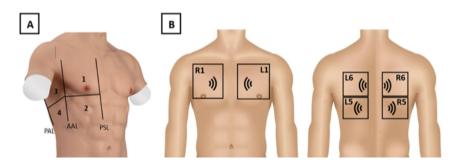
Lung Ultrasound Protocols. (A) The four chest areas per side considered for complete eight-zone lung ultrasound examination, used to evaluate the presence of interstitial syndrome. According to Volpicelli et al, the interstitial syndrome is present when there are \geq 3 B-lines in two or more regions bilaterally of the anterior and lateral thorax. (B) Six chest zones assessed on short ultrasound examination.
